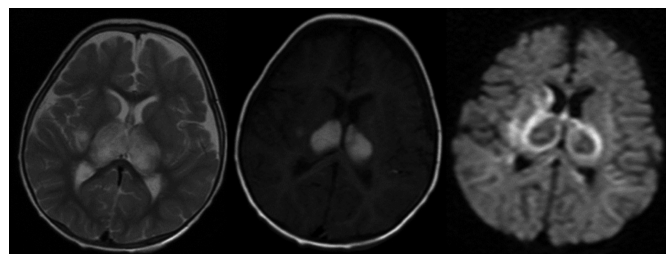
MR brain T2-weighted (T2W) and (T1-weighted) T1W axial sections reveal swollen bilateral thalami with signal abnormality. Note the classic "Double Doughnut sign" on susceptibility-weighted imaging (SWI) sequences.
